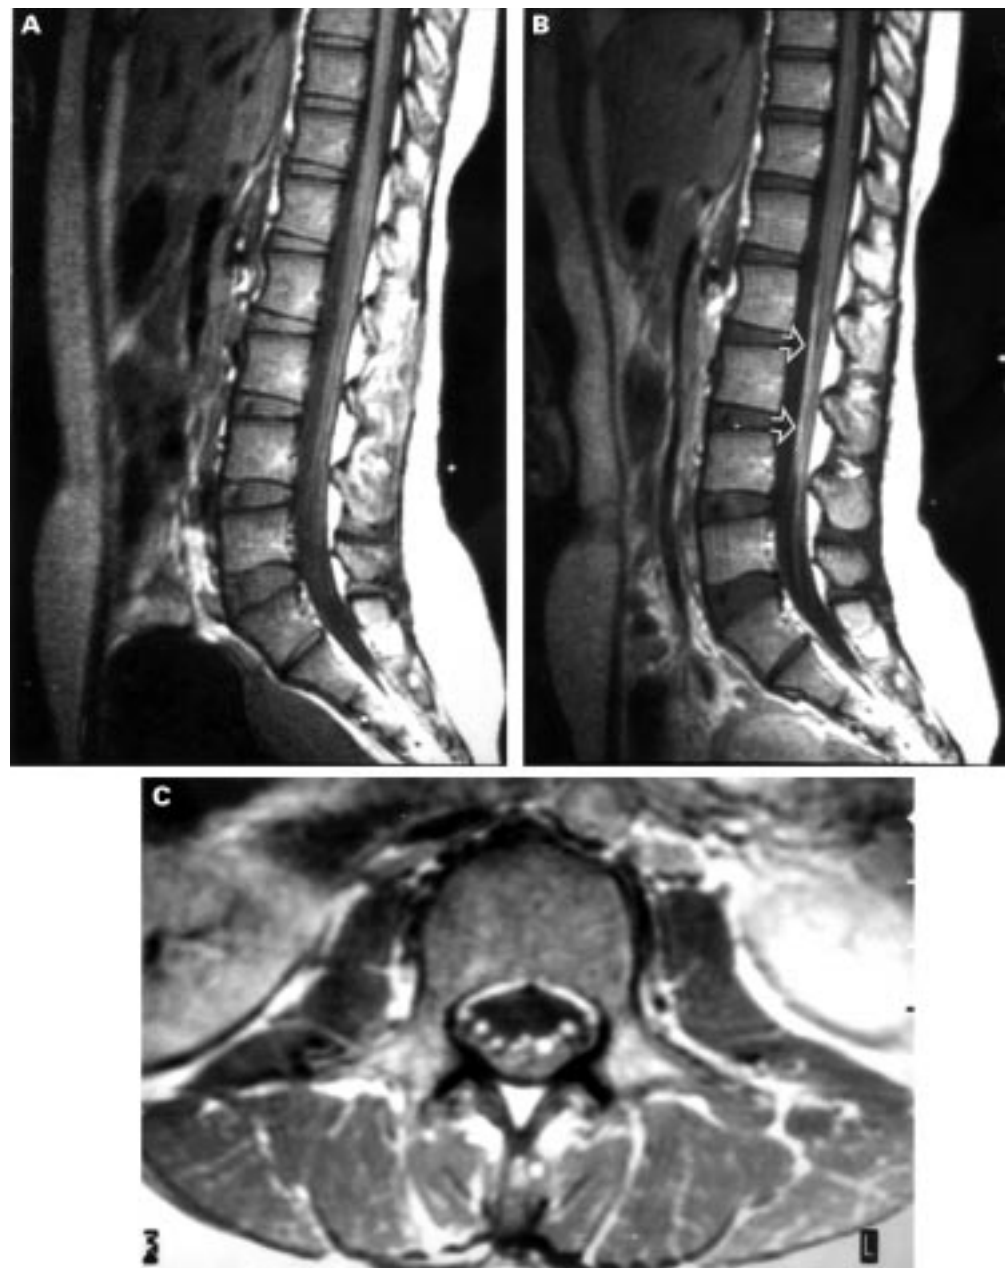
MRI of lumbar spine: sagittal T1 weighted images before (A) and after (B) gadolinium show enhancement of a nerve root along its entire length (arrowheads). Axial T1 weighted gadolinium enhanced images at the L4/L5 level (C) show multiple enhancing nerve roots in cross section.
